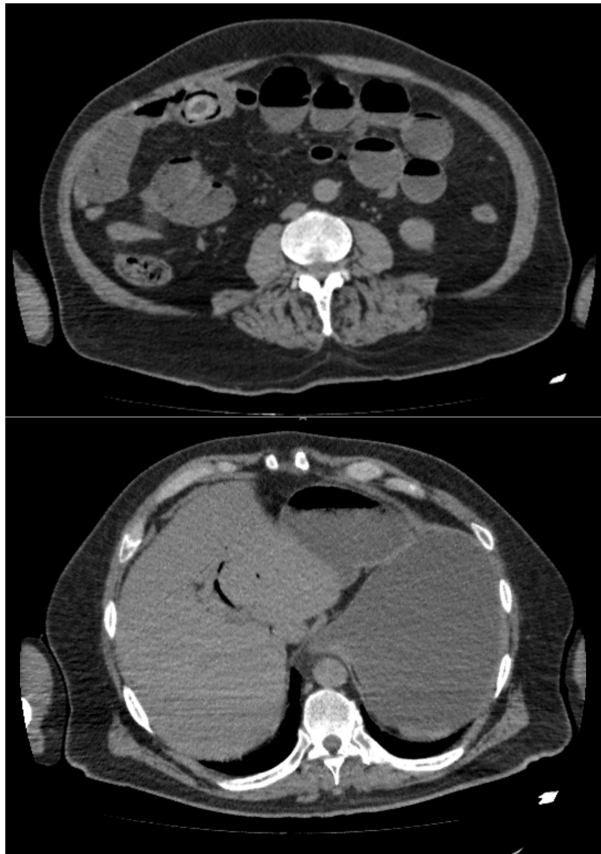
CT scan with distension of intestinal loops and ectopic biliary stone. (Lower): pneumobilia
